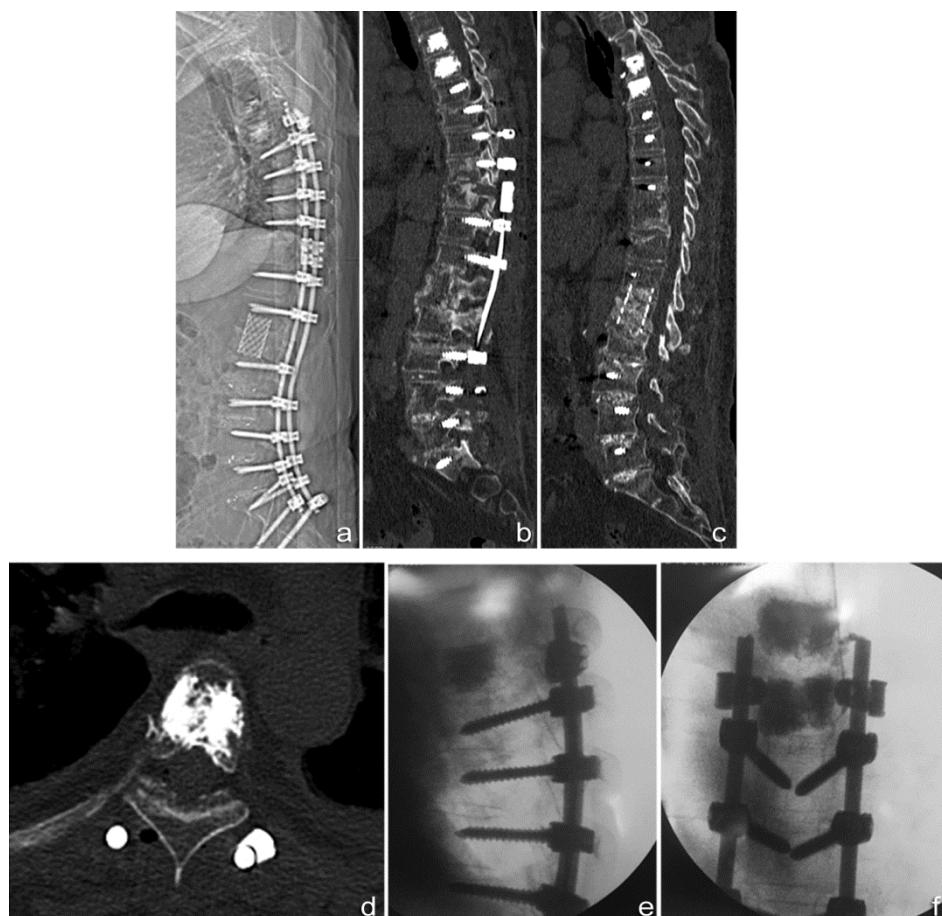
Control radiographs and CT scans of the spine of patient S. after the completion of surgical treatment. The spine is fixed by an extended hybrid metal structure from Th5 throughout to Os Ilium (a, b, c). At the Th9–Th11 level, the connectors (a, b) vertebroplasty (d, e, f) in the bodies of Th4, Th5 are seen. Th5 level is fixed with the laminar band "Universal Clamp" (e, f)
